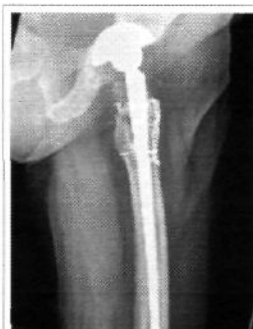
Case 3: Full-length radiograph showing fracture through distal third portion of stem
